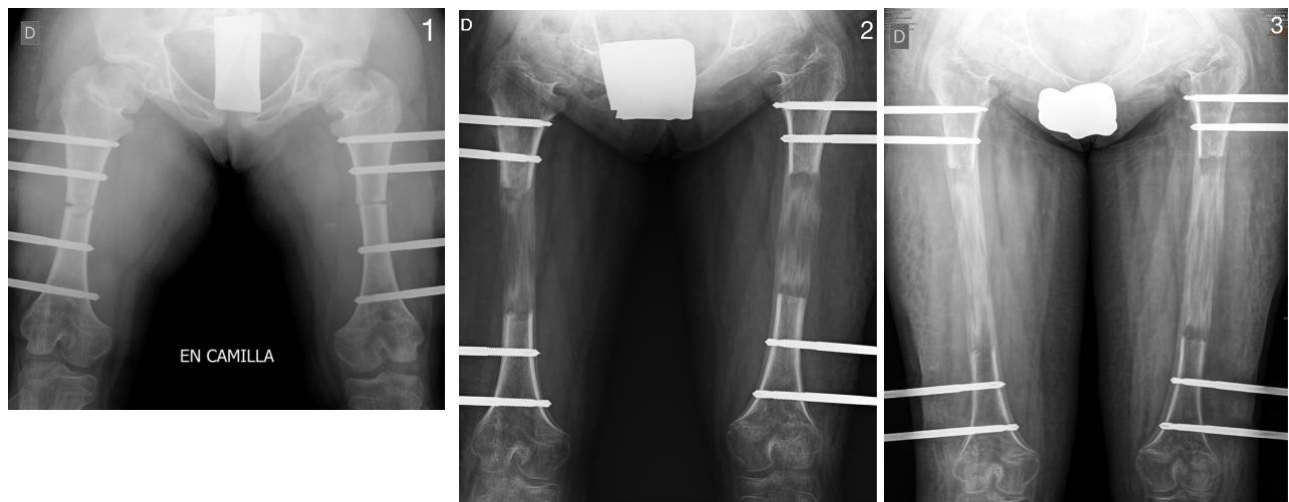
Radiograph after osteotomy surgery with implantation of external fixator. Procedure is performed bilaterally, so on both femora. Figure 2. Follow-up at 8 cm lengthening. Notice ossification callus formation. Figure 3. Follow-up at 15 cm lengthening. Ossification callus with increased density.
